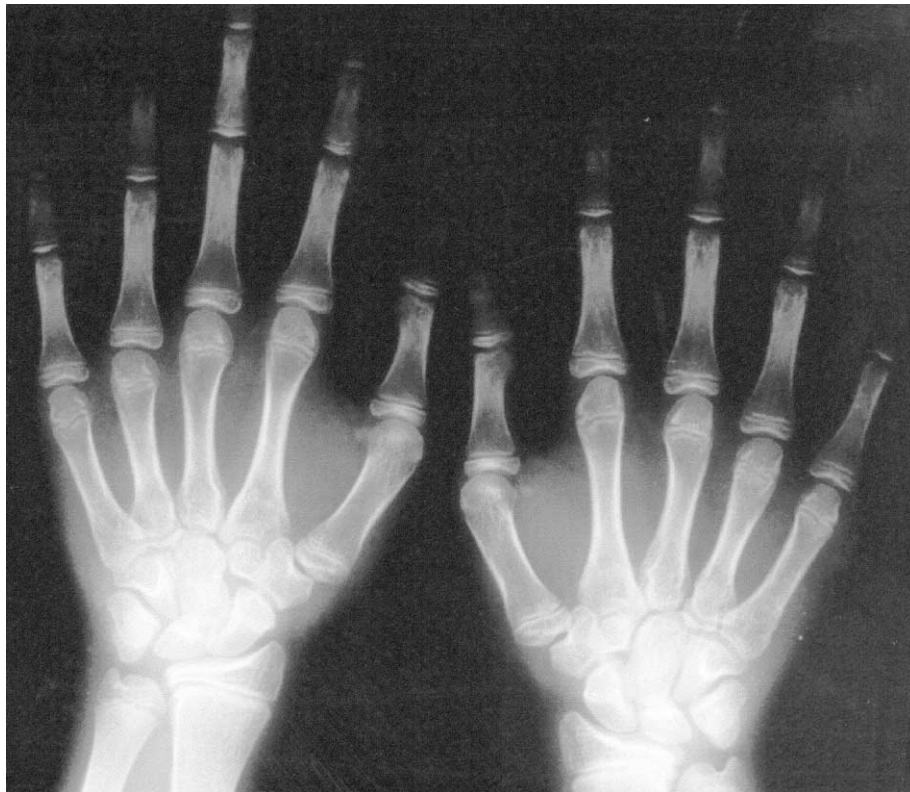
Radiographs 24 months after the cold injury and HBO<sub>2</sub> treatment. Normal appearance of the epiphyseal structures.
